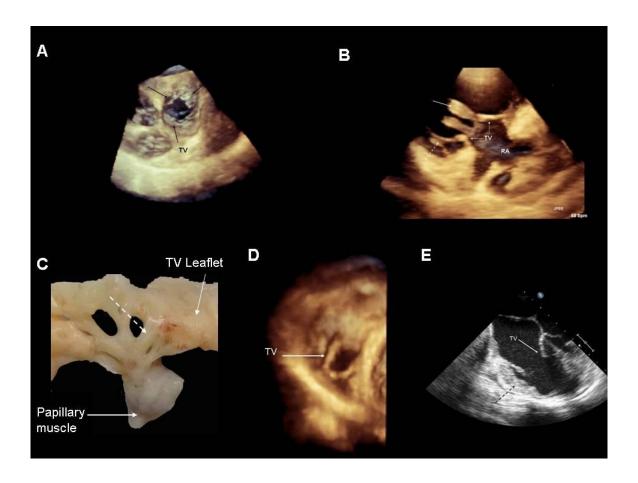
Three dimensional Transthoracic Echocardiogram.
